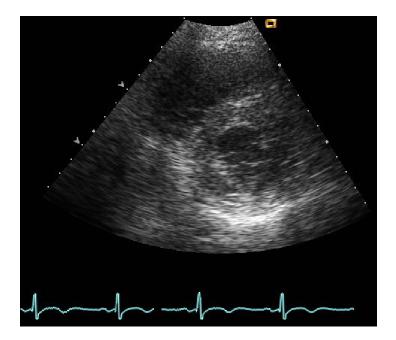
The same patient as in figure 7 showing no flattening of the septum in short axis view of echocardiographic image
